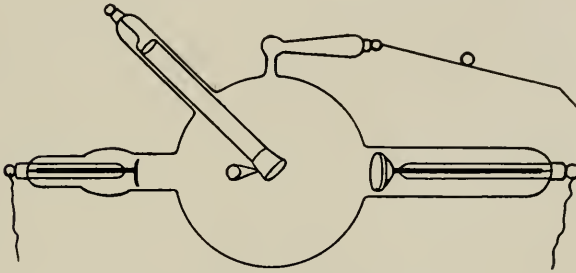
High-frequency X-ray tube.
